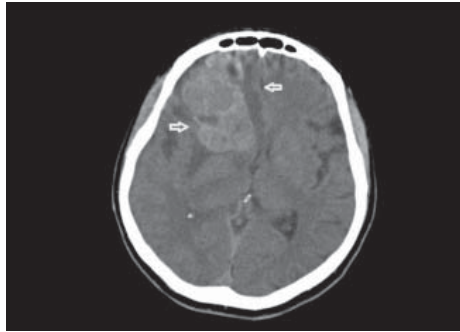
A mass in the right frontobasal region of cranial CT (between the arrows).
